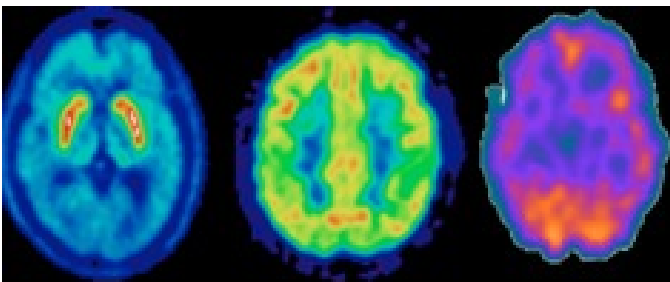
Functional axial images (PET DOPA, left image; PET-FDG, middle image; SPECT, right image). Note the difficulty in identifying brain structures in functional sections.
